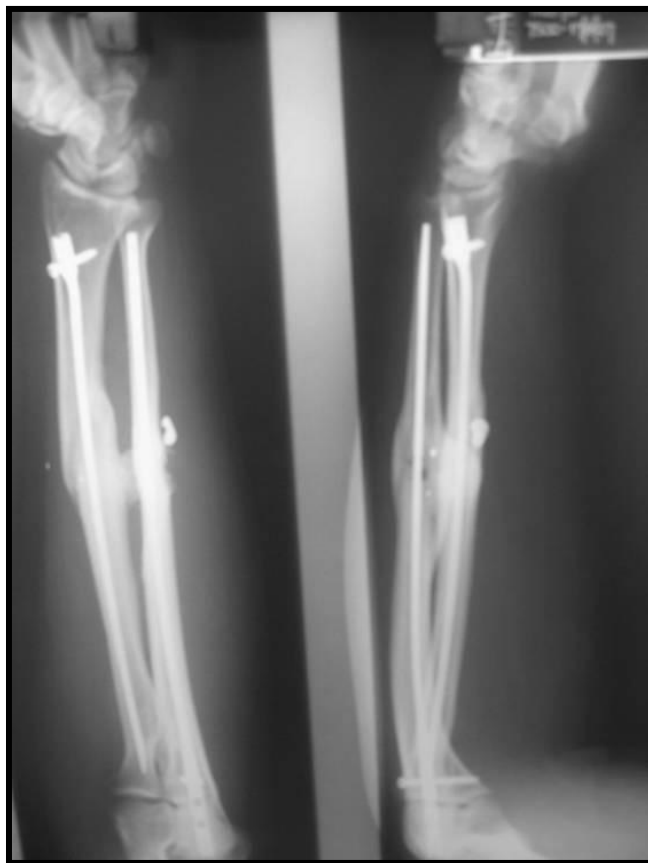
X-ray at six months of patient in figures 8-13
